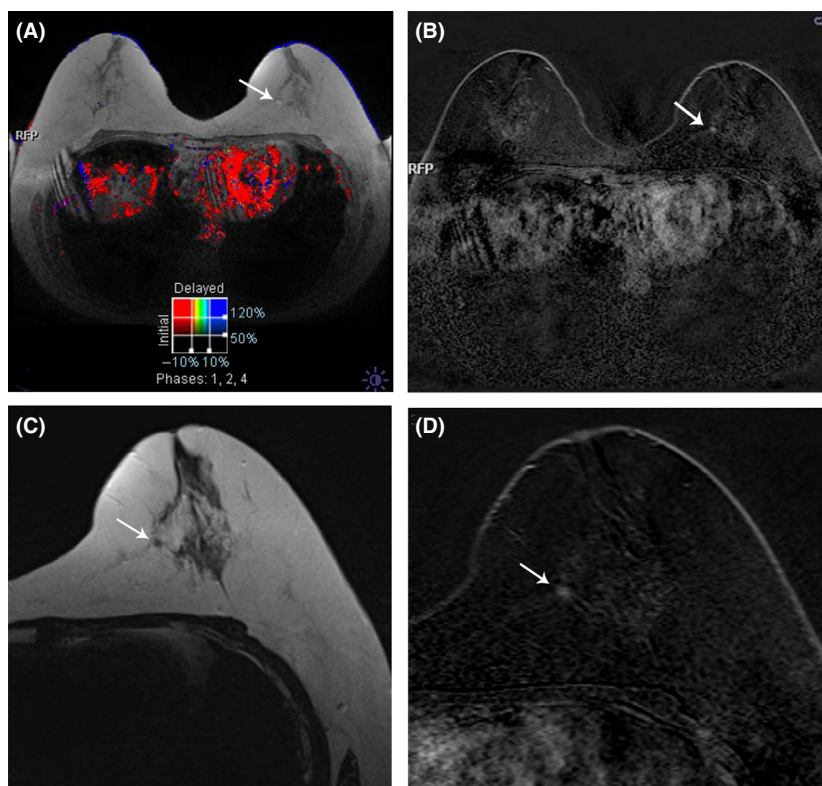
Thirty six-year-old woman with past history of mantle radiotherapy for Hodgkins disease at the age of 13. There was also a family history of breast cancer in two first degree relatives (bilateral in one). Contrast-enhanced MRI: (A) colour map first post-contrast T1-weighted sequence; (B) first post-contrast subtraction; (C) enlarged T2-weighted image of left breast; and (D) enlarged first post-contrast T1-weighted subtraction image. A 5 mm enhancing focus is noted in the lower inner quadrant of the left breast (arrow) too small to characterise, but not showing worrying kinetics on the colour map. The lesion was not visible on a targeted ultrasound scan and the mammogram at this time (Fig. 9A) was normal. A repeat MRI in 3–6 months was recommended to assess stability.
